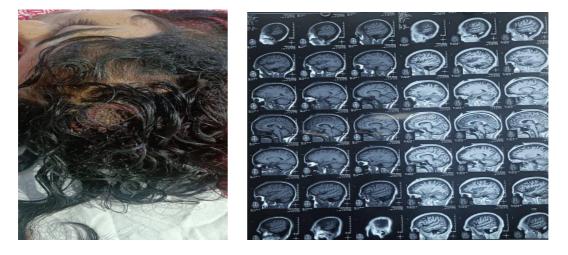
shows MRI shows lacerated wound with normal brain parenchyma. FIG1b)
